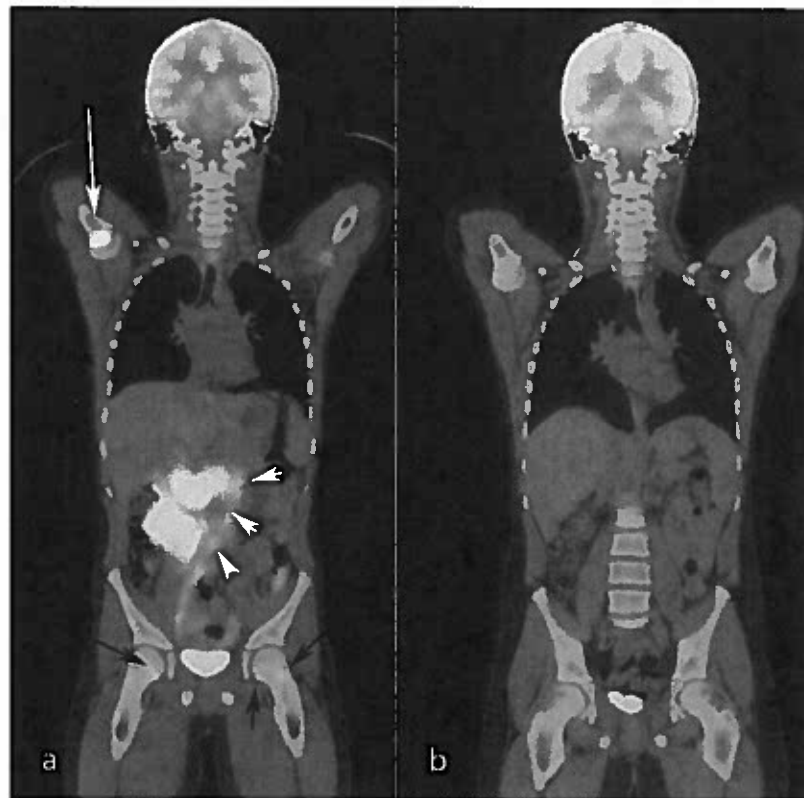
a and b Lymphoma PET CT.
